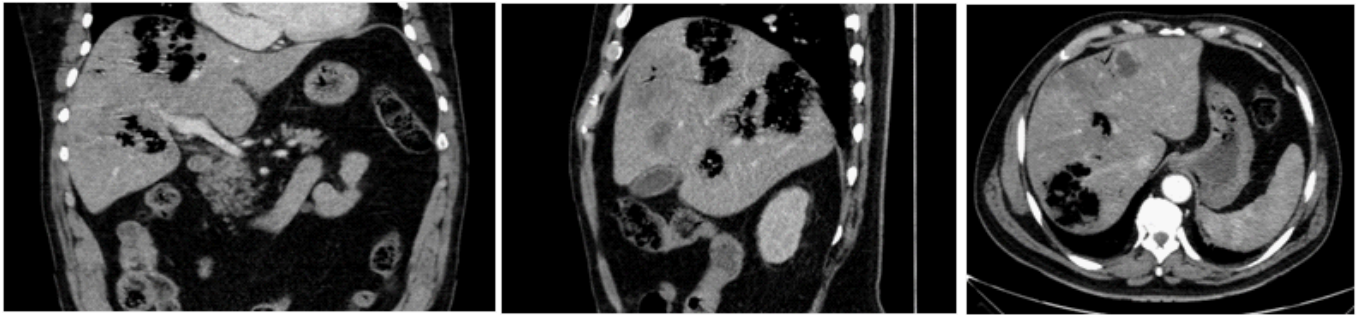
Abdominal CT - the images above show the multiple confluent gas-containing lesions on the right lobe, the two largest measuring 6 and 7 cm, extending to the periportal space, with a spared hepatic left lobe (only hypodense lesions compatible with biliary cysts), in sagittal, coronal and horizontal views (left, middle and right, respectively). No pathogenic findings on the hepatic arteries, portal vein, spleen, pancreas or other organs were identified.
